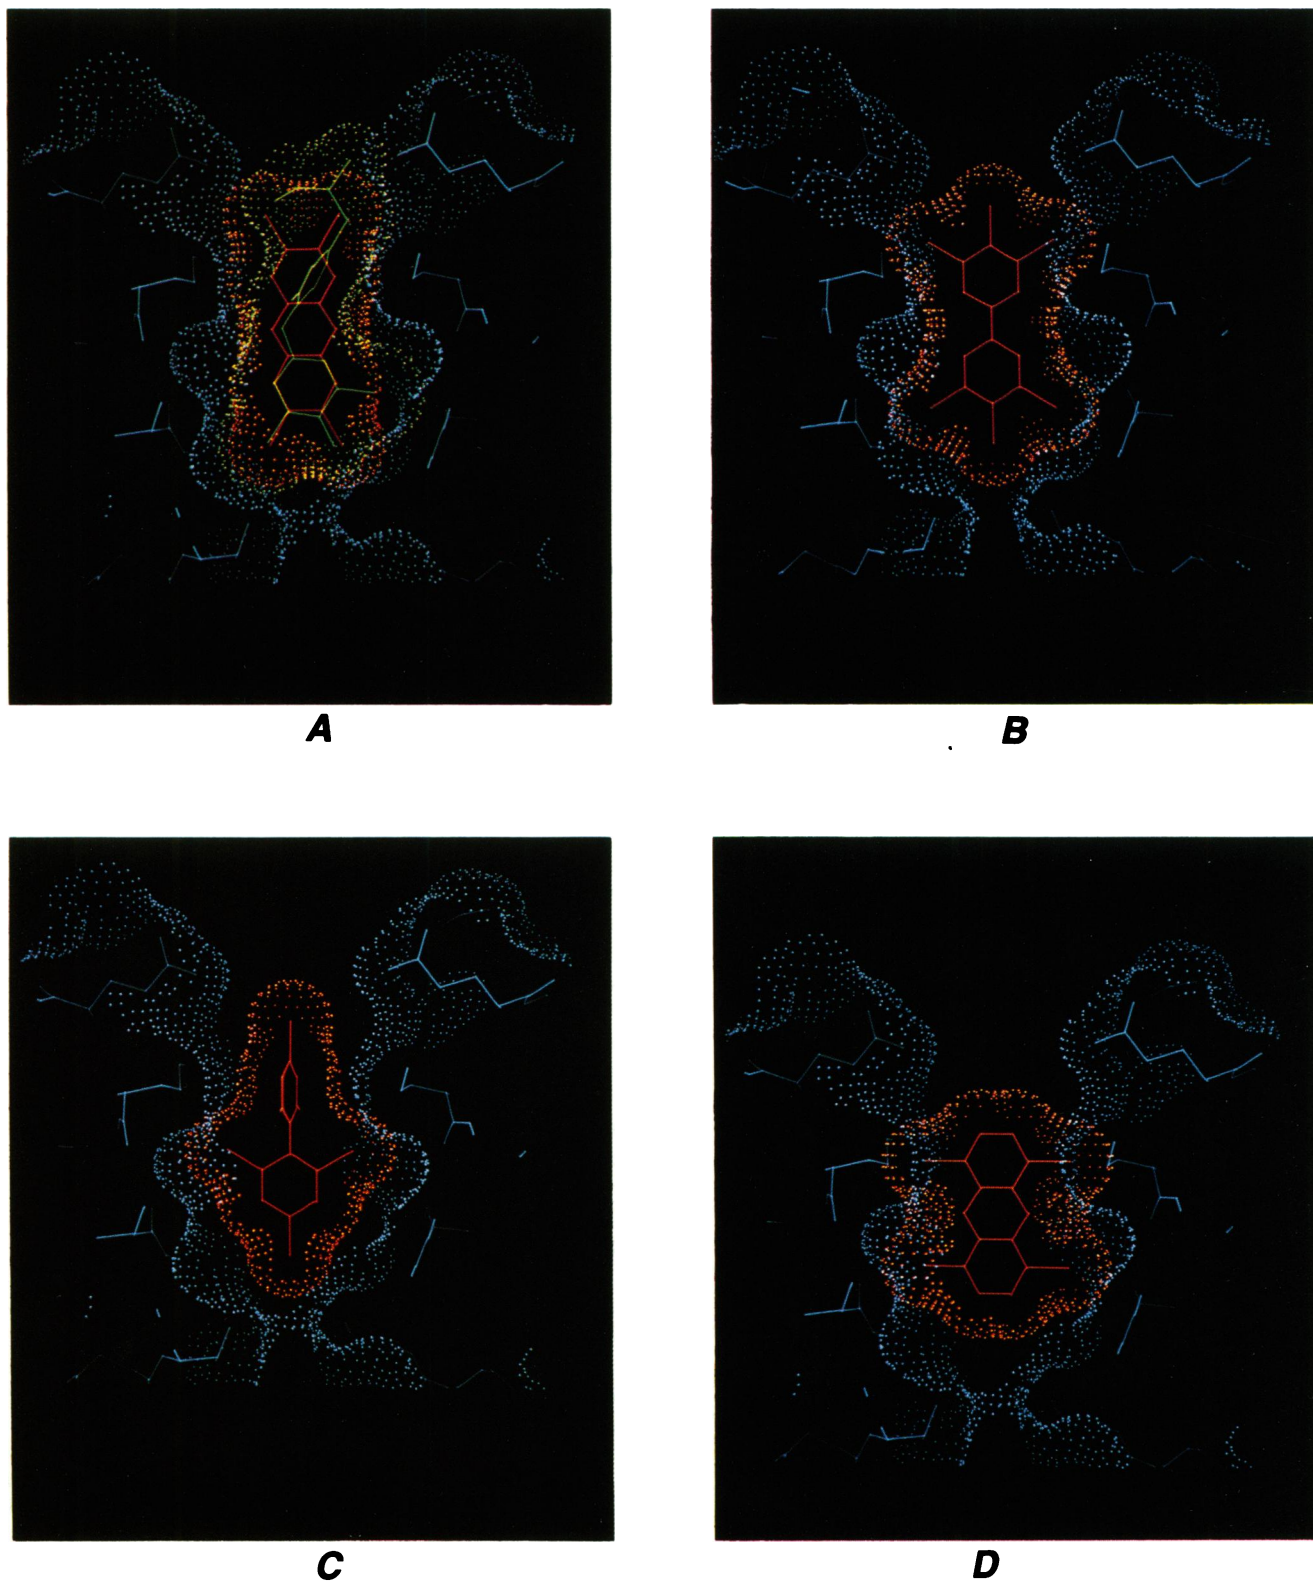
Computer graphic models of ligand-TBPA binding pocket complexes. Pictures show cross-section of solvent-accessible molecular surfaces of the model-built binding site (view is perpendicular to plane of inner ring). The TBPA surface is blue. (A) Superposition structure of T₄ (green) from X-ray and TCDD or dioxin (red) from docking; (B) docked 3,3',4,4',5,5'-hexachlorobiphenyl; (C) docked 2,2',4,4',6,6'-hexachlorobiphenyl; (D) docked 1,4,6,9-tetrachlorodibenzo-*p*-dioxin.
